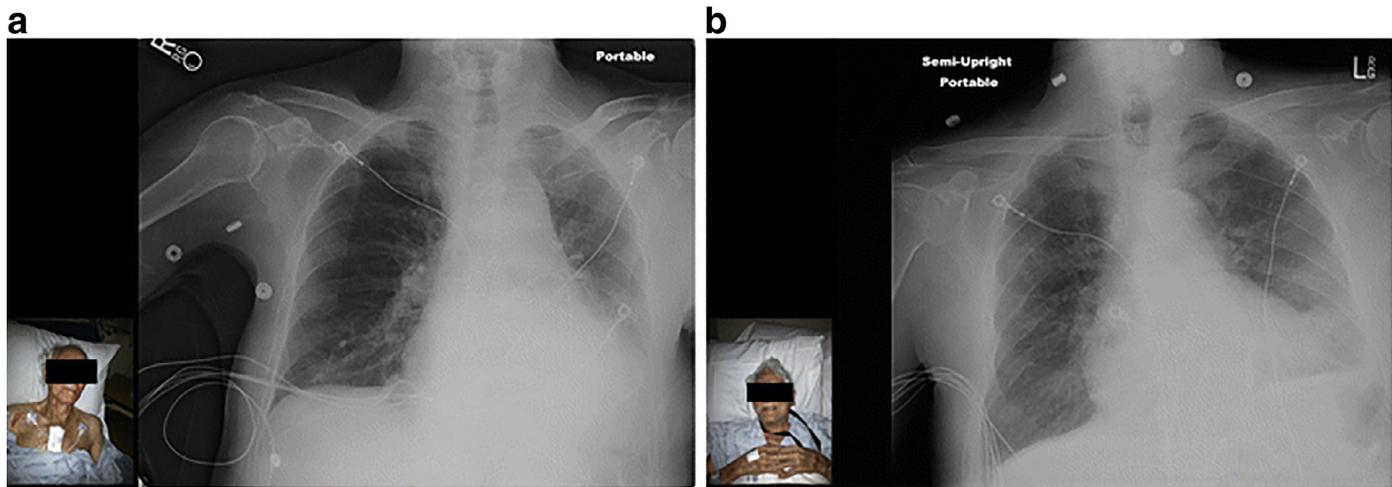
Example Photograph–Radiograph
